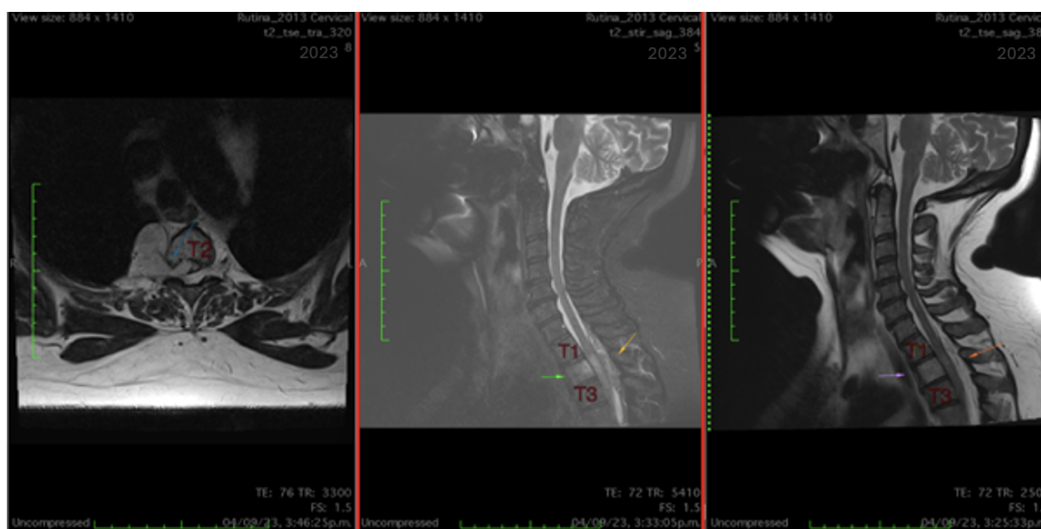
Thoracic spine MRI.
